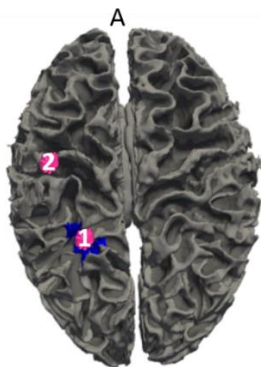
Source localisation for Patient P074 using Solution 1, 2, 3, 4 and validations. (a) Solution 1 and (b) Solution 2 were localized to right parietal convexity. (c) Solution 3 with kurtosis value 4.51 localized to right middle occipital gyrus. (d) Solution 4 localized to an extended area including posterior right temporal lobe and right parietal convexity. The subfigures of (a), (b), (c) and (d) show the corresponding sources registered onto the MRI images. In the colour maps shown in (a), (b) and (c), yellow represents the highest kurtosis value and red represents the lowest values. (e) The validations used in this study, in which surgically resected areas are indicated by the blue surface and pink discs indicate the clinically localized results. In clinical EEG-MEG source localisation, the onset of source located at junction of the post-central sulcus and superior parietal lobule, then propagate to Ipsilateral pre-central gyrus. The onset and propagation are shown by the pink discs with number 1 and 2, respectively, in (e). The anterior of the brain is indicated by the 'A' in (e).
